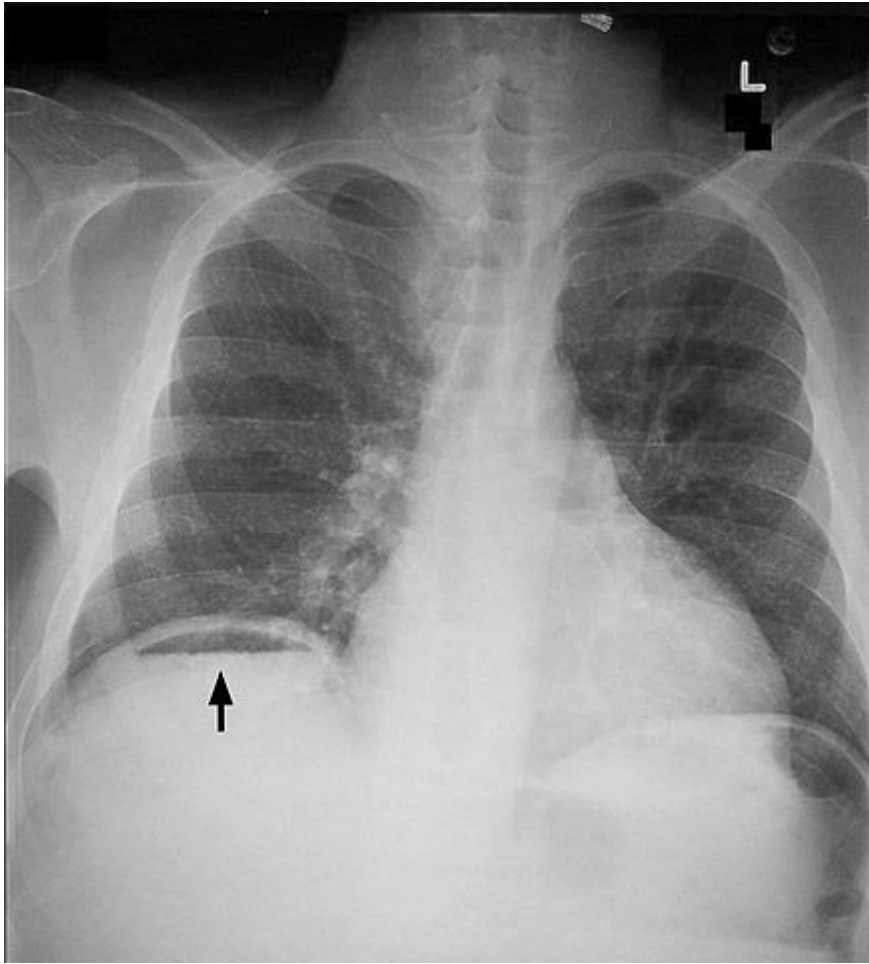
"Pneumoperitoneum on chest X-ray." by Clinical_Cases. License: [CC BY-SA 2.5](https://creativecommons.org/licenses/by-sa/2.5/)
